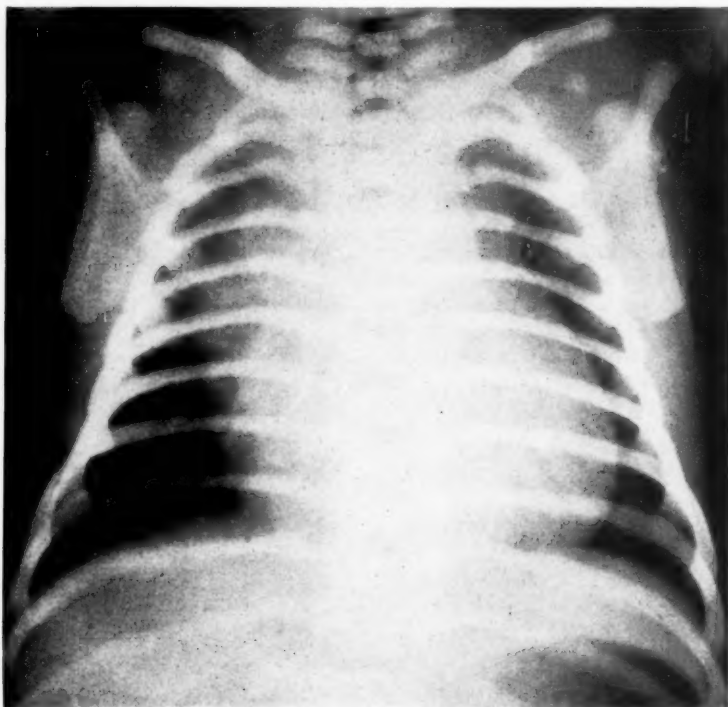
Roentgenogram of chest in Case 2. The heart is enlarged. Described in text.
